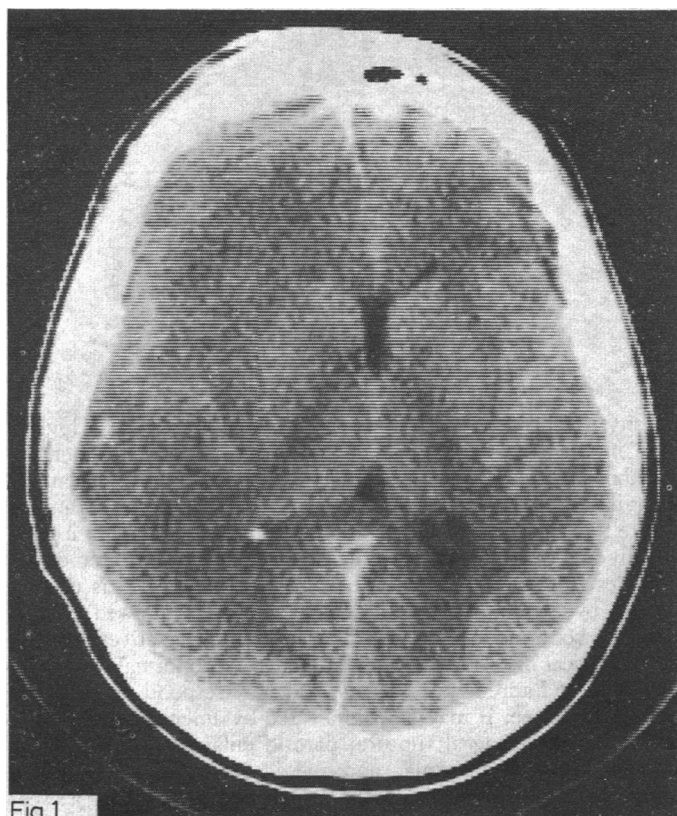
Case 1. CT scan in subdural empyema showing midline shift to left and an isodense subdural collection over right hemisphere.
